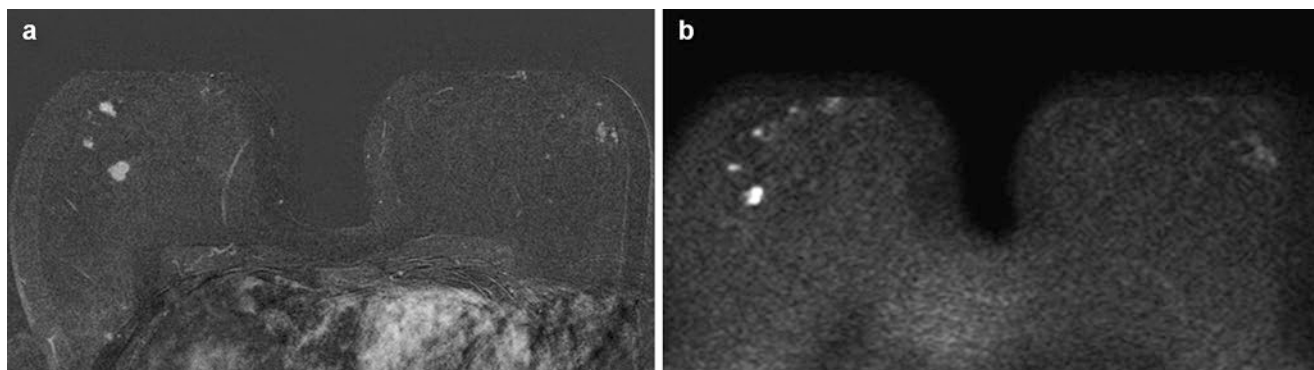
Utility of abbreviated breast MRI, and un-enhanced diffusion-weighted imaging in a 52-year old woman at average risk undergoing MRI screening; her mammogram was normal. (a) First post-contrast subtracted or FAST image, generated by subtracting the image obtained within 60 s after contrast injection from the pre-contrast
